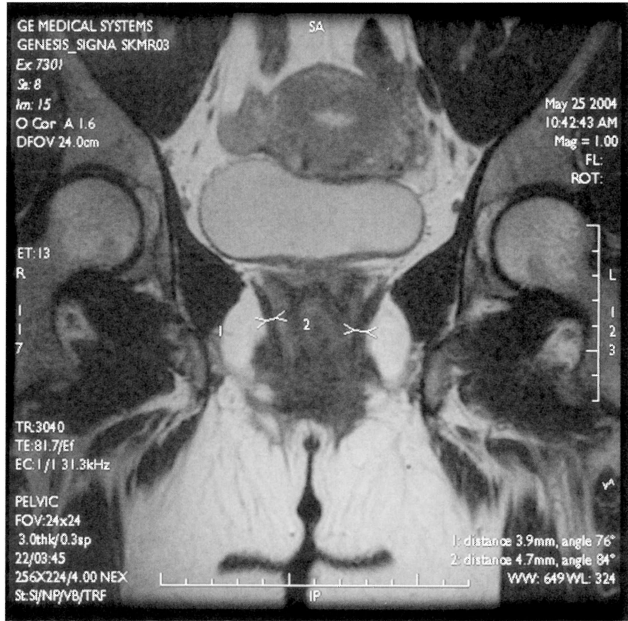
Coronal MRI measurement of the levator ani. The axial slices were placed parallel to a line running from the tip of the coccygeal bone to the bottom of the symphysis. The coronal slices were perpendicular to the axial plane. The bony landmarks noted were the pubic bone and the tuberal region of the ileococcygeal bones. The coronal measurements of the thickness of the levator ani were performed at the level of the middle of the urethra, placed so that the rectum had the same distance to the bony landmarks at both sides.
